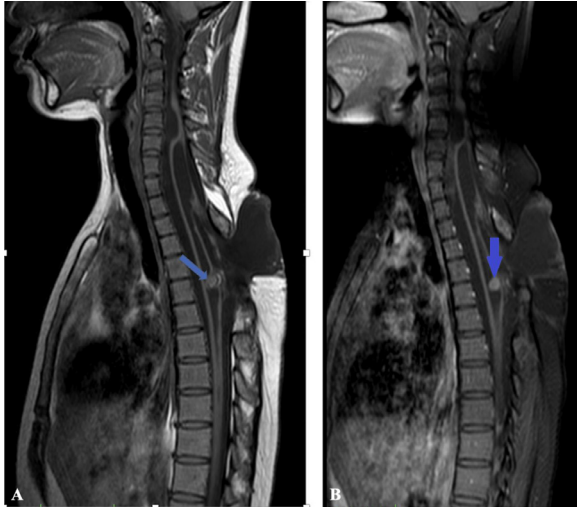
MRI Sagittal images (Figure 4A-Pre-contrast T1 weighted image, Figure 4B-fat saturated T1 post-contrast image) demonstrate low signal intensity lesion in the central canal of the spinal cord corresponding to D6 vertebral body (blue arrow in Figure 4A) which shows significant enhancement on post-contrast image (blue arrow in Figure 4B). However, no other enhancing lesion/s was noted in the rest of the visualized spinal axis.
